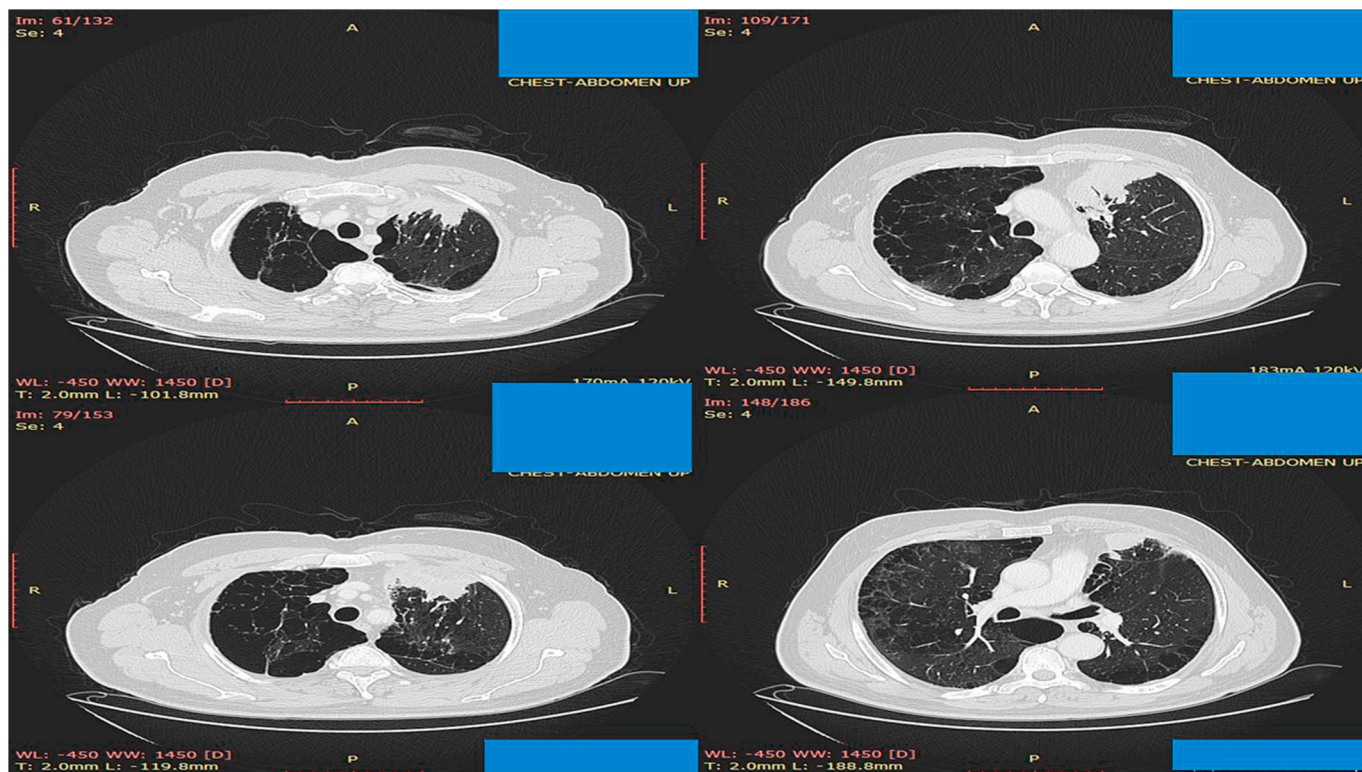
CT of the thorax upon diagnosis.
